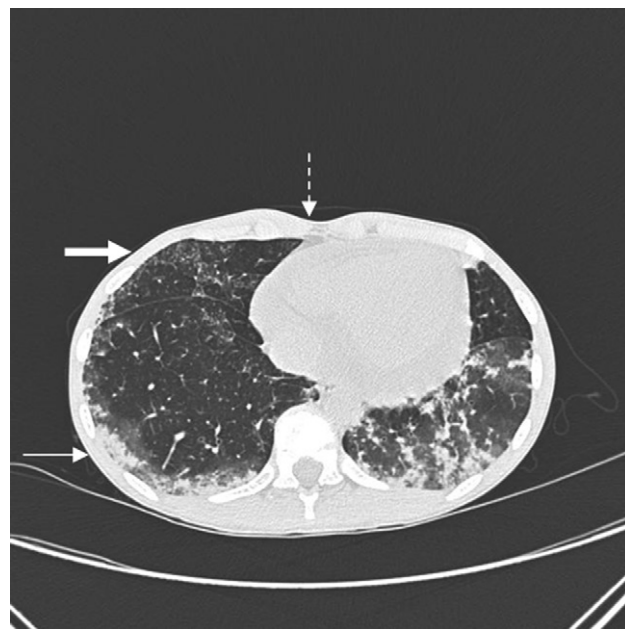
Chest computed tomography (before treatment with prednisone) revealing bilateral pulmonary infiltrates with lower lobe predominance (small arrow), peripheral consolidations (thick arrow) and some pericardial effusion (interrupted arrow).
